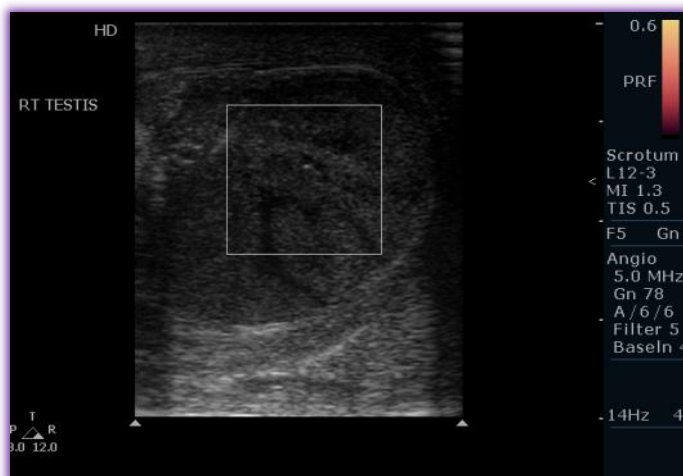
Longitudinal scan with power Doppler showing hypoechogenicity and absence of flow in testis. (Case 21)
